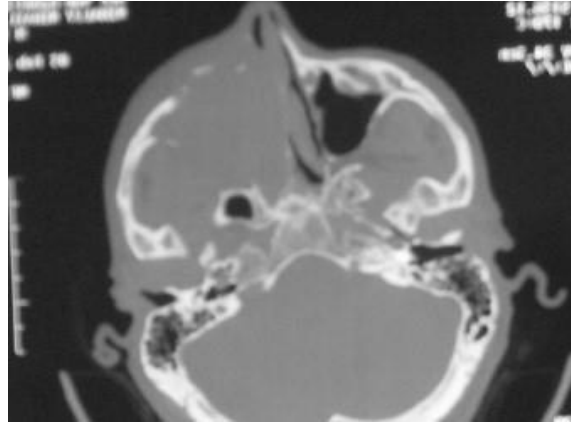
shows axial CT bony window with melanoma in rt maxillary and nasal sinuse (<https://www.sciencedirect.com>)
